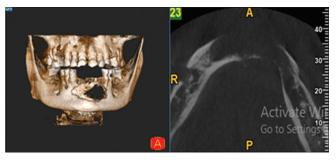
Cone-beam computed tomography images showing a buccal and lingual cortex disrupted
